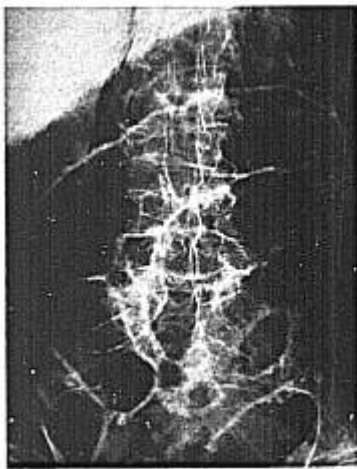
Post mortem roentgenogram showing air in and around the psoas muscles. The patient was a 67 year old man who died of air embolism during pneumoencephalography.
